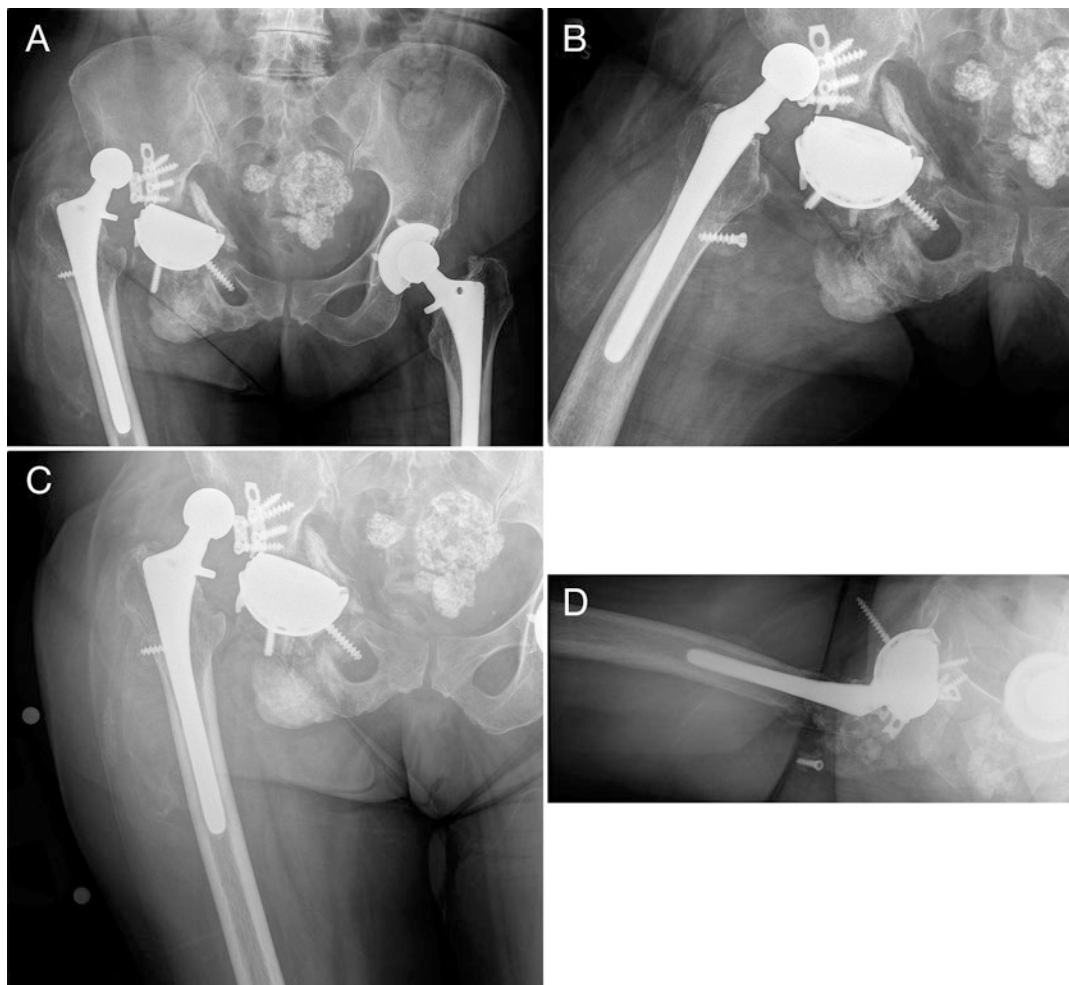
(a) Anteroposterior (AP) pelvic, (b) oblique, (c) AP hip, and (d) cross-table lateral radiographs of the above patient when she presented to our institution several weeks later. In conjugation, the radiographs reveal an
